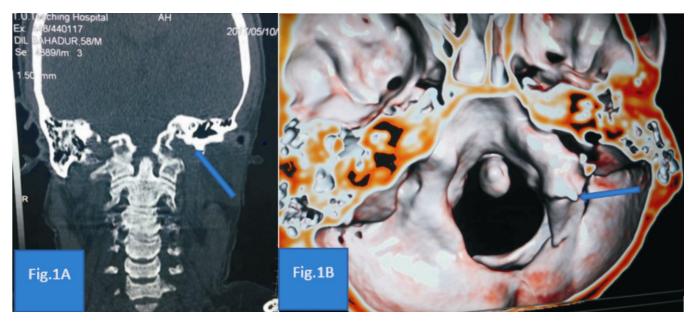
Computed tomography. Coronal view of right occipital condylar fracture arrow head (A) and Axial 3D reconstructed image showing fracture line arrow head (B).
